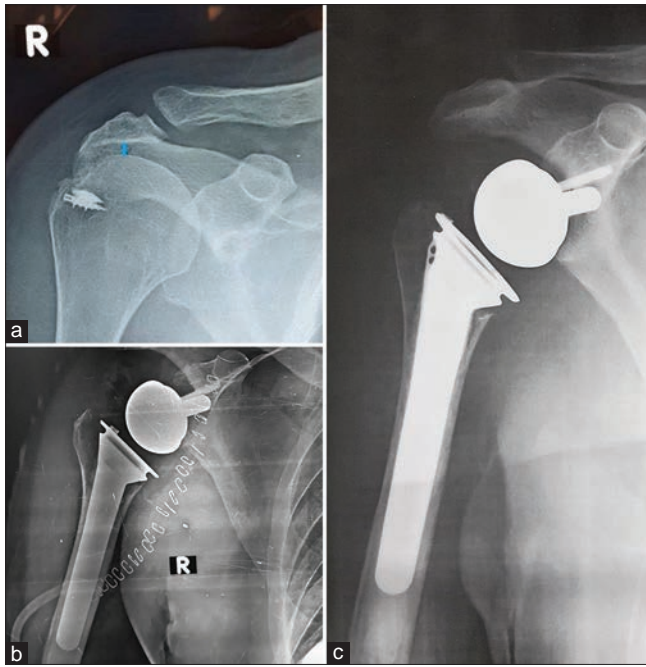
(a) Preoperative plain X-rays, (b) Postoperative X-rays of irreparable cuff tear patient, (c) last follow-up plain X-rays
